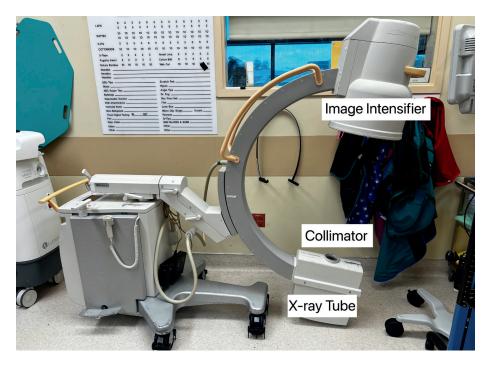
Fluoroscopy unit components. The x-ray tube emits x-rays. The image intensifier captures x-ray beams and converts them into an image. The collimator uses apertures to determine the shape and size of the x-ray beam.
